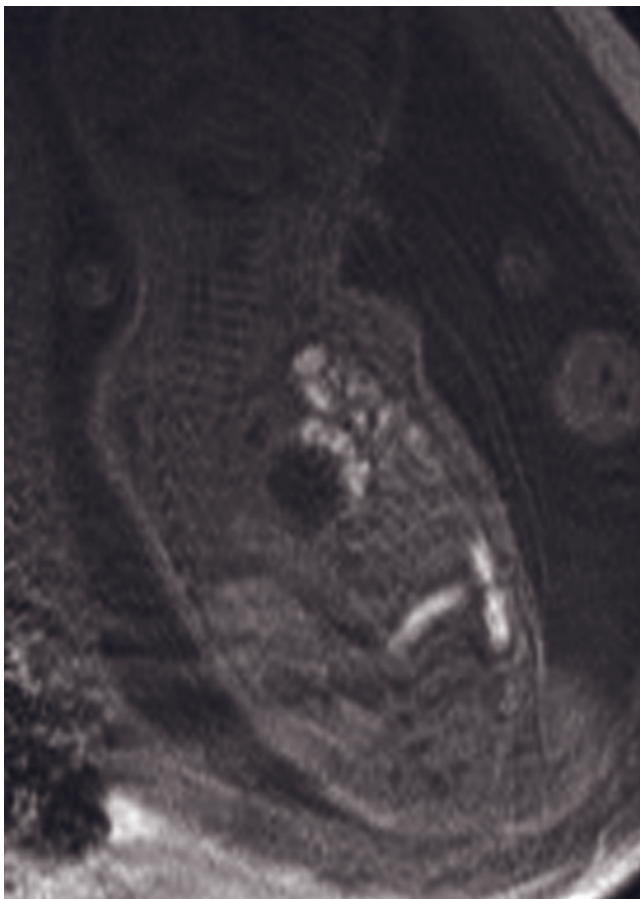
Congenital diaphragmatic hernia. Transverse (a) and coronal (b) T2-weighted SS-ETSE images through the fetal torso in the second trimester show stomach (s, a, b) and small bowel (sb, b) in the left fetal chest. A small portion of fetal lung (white arrow, b) is seen at the apex. The transverse image shows the heart (black arrow, a) abnormally located in the right chest and the right lung (white arrowhead, a) posteriorly. The hernia contains liver (black arrow, a), which is associated with a worse outcome. Note normal second-trimester fetal kidneys (black arrows, b). Coronal T2-weighted SS-ETSE images (c and d) in a different
